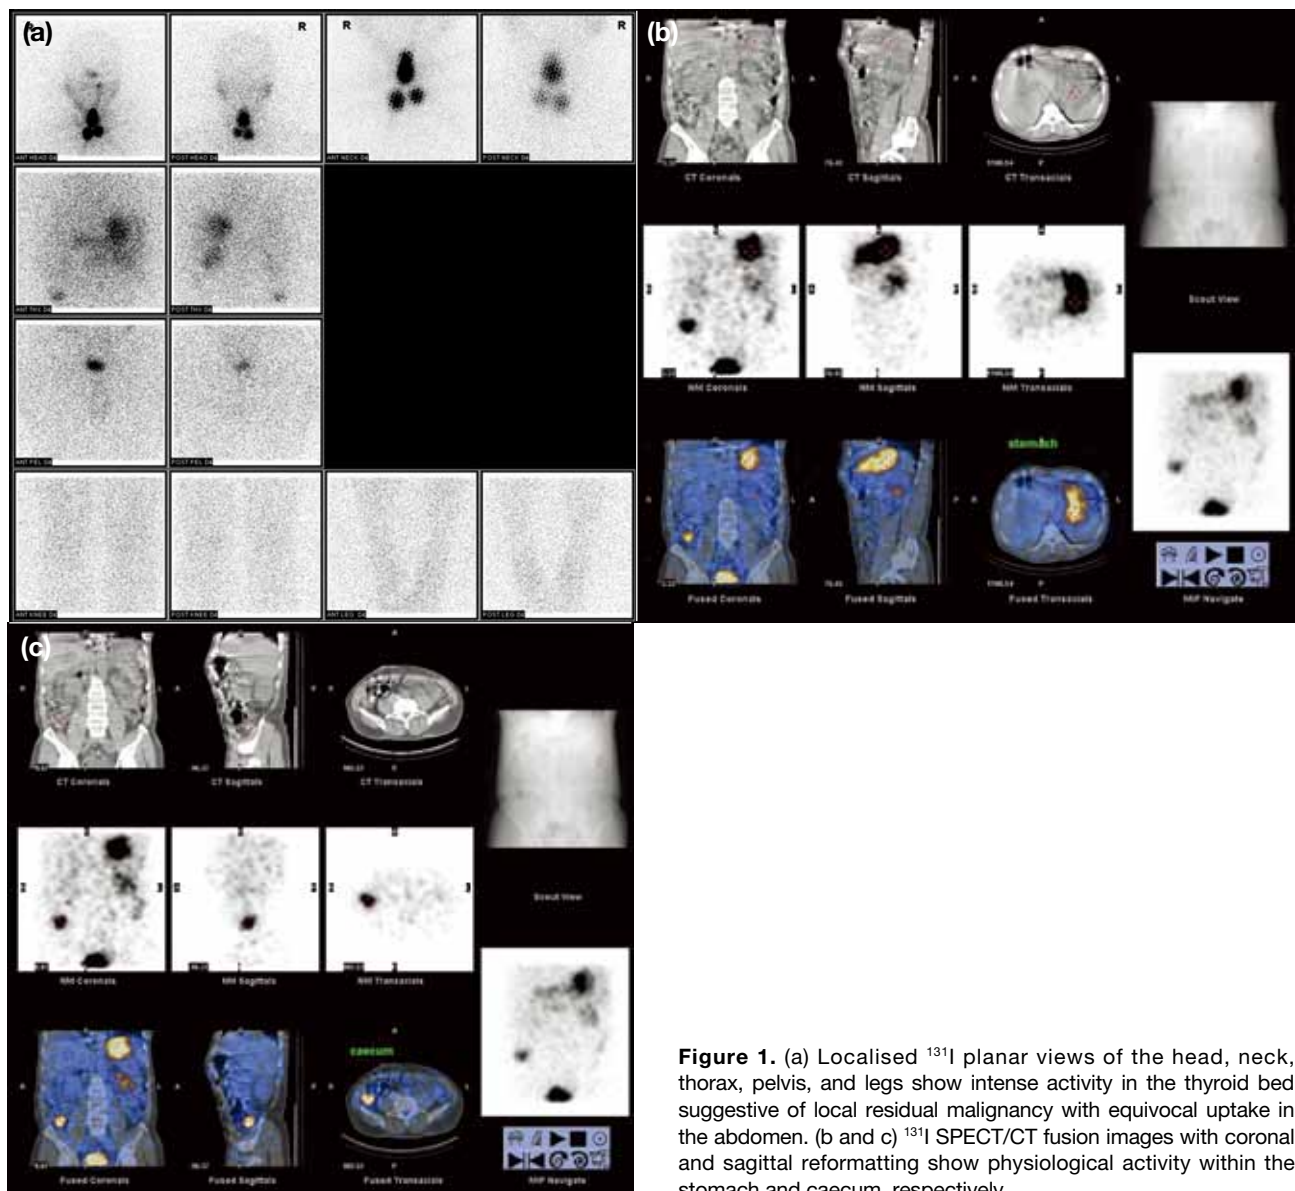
(a) Localised ¹³¹I planar views of the head, neck, thorax, pelvis, and legs show intense activity in the thyroid bed suggestive of local residual malignancy with equivocal uptake in the abdomen. (b and c) ¹³¹I SPECT/CT fusion images with coronal and sagittal reformatting show physiological activity within the stomach and caecum, respectively.
